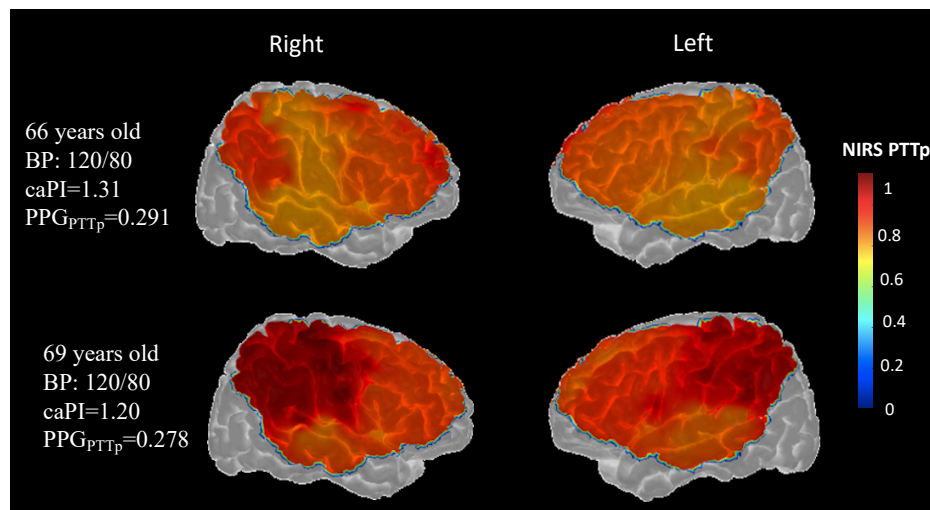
Spatial distribution of normalized cerebral pulsatility for 2 different older adults projected on the cortex. As we can see in this figure, even though the blood pressure is identical for these two individuals, the cervical blood flow pulsatility (caPI; measured with PC-MRI) and the spatial distribution of NIRS_{PTTp} are different. Interestingly, 69 years old individual shows lower pulsatile stress, especially in the parietal subregions compared to 66 years old participant. Our results show that cerebral pulsatility is not always evident from measure of blood pressure in peripherally and needs to measure in the brain.
